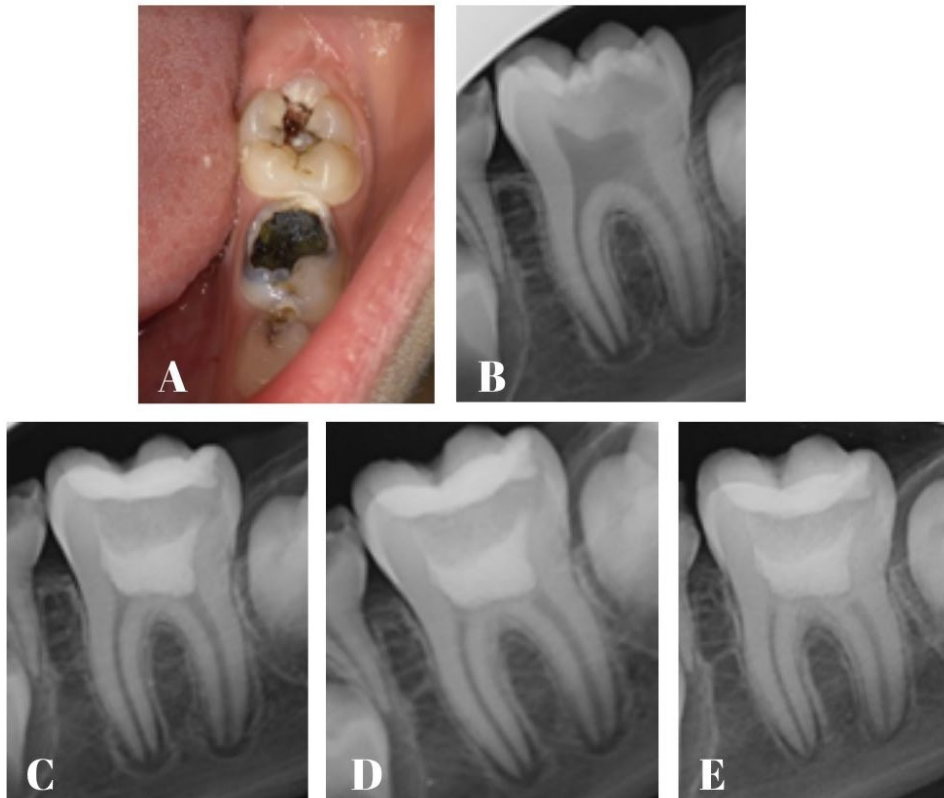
A: Preoperative photograph showing tooth 14 with deep dentin caries, B: Preoperative radiograph of tooth 14, C-D-E: 6,12 and 18 months follow-up.
